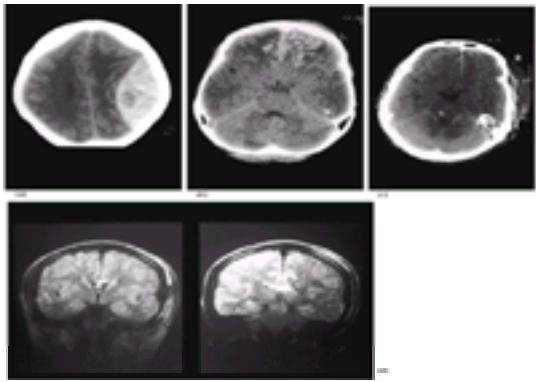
Examples of CT and magnetic resonance imaging (MRI) abnormalities seen after blunt head injury. (a) CT of an extradural haematoma; (b) CT of bilateral frontal contusions; (c) CT of deep-seated parenchymal haematomas including a haematoma in the brainstem; (d) coronal MRI scan showing the type of focal lesion seen after severe, diffuse axonal injury.
